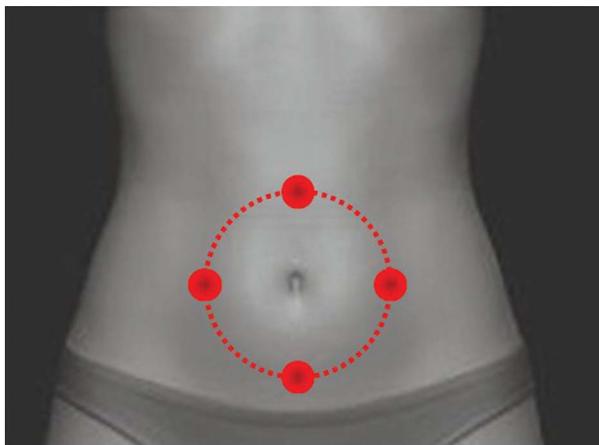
Visualization of ultrasound measurement points.
